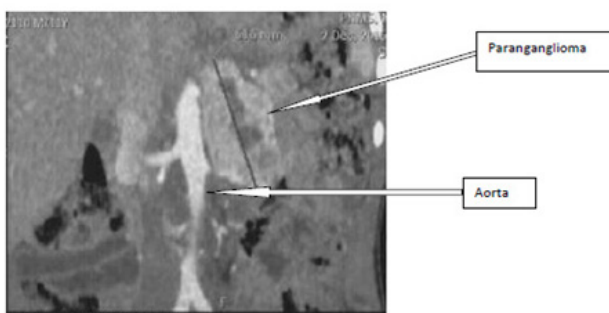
CT scan peritoneal tissue process localized at hilar renal left intensely intensified and heterogeneous at arterial time with foci of necrosis.
